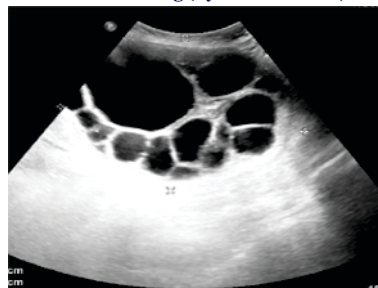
Ultrasonography Shows Evidence Of Multiple Various
